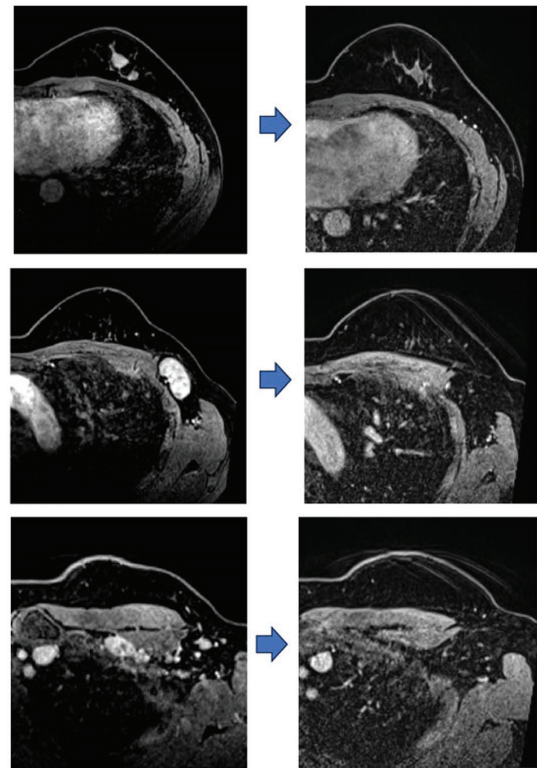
MRI images of breast cancer before and after the start of chemotherapy. The image on the left depicts the patient's condition prior to the initiation of treatment, whereas the image on the right shows the patient's condition after ceasing immune checkpoint inhibitor therapy. The tumor has become undetectable on MRI.
